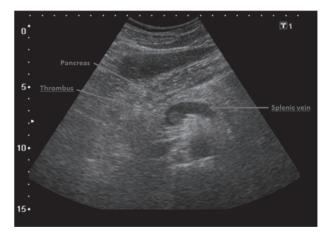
Ultrasound still showing a hyperechogenic reflection located in the splenic vein near the venous confluence
